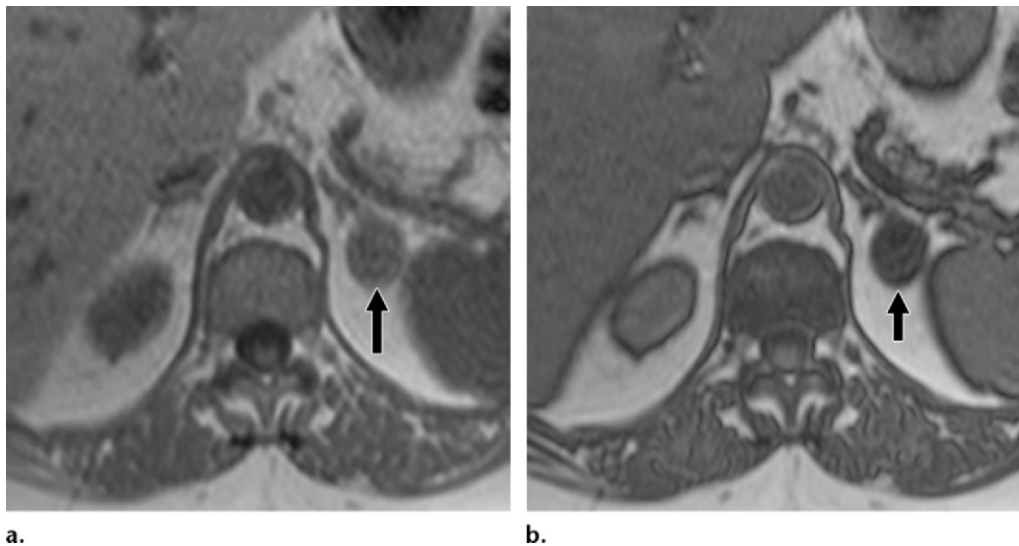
Adrenal adenoma in a 43-year-old woman. Axial in-phase (a) and opposed-phase (b) T1-weighted MR images show a left adrenal mass (arrow). The mass shows signal intensity loss on the opposed-phase image compared with the in-phase image, owing to intracellular fat content.
